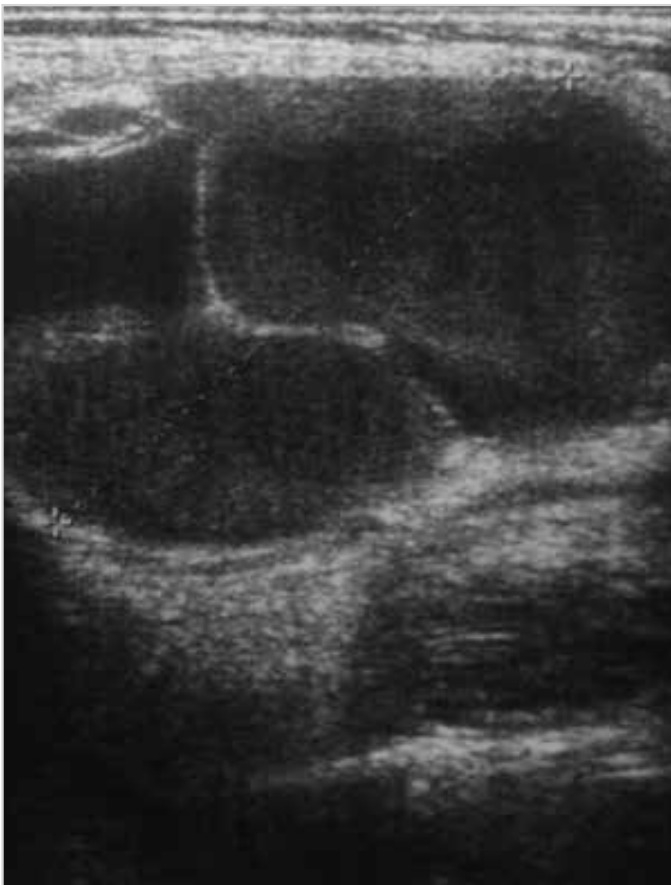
Ultrasound scan showing a 55×40×35 mm, multilobulated, homogenous, cystic mass on posterolateral border of sternocleidomastoid (SCM) muscle in the right supraclavicular region
